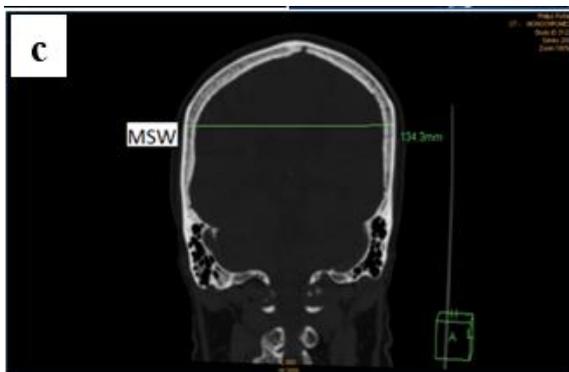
CT image showing the MSW
